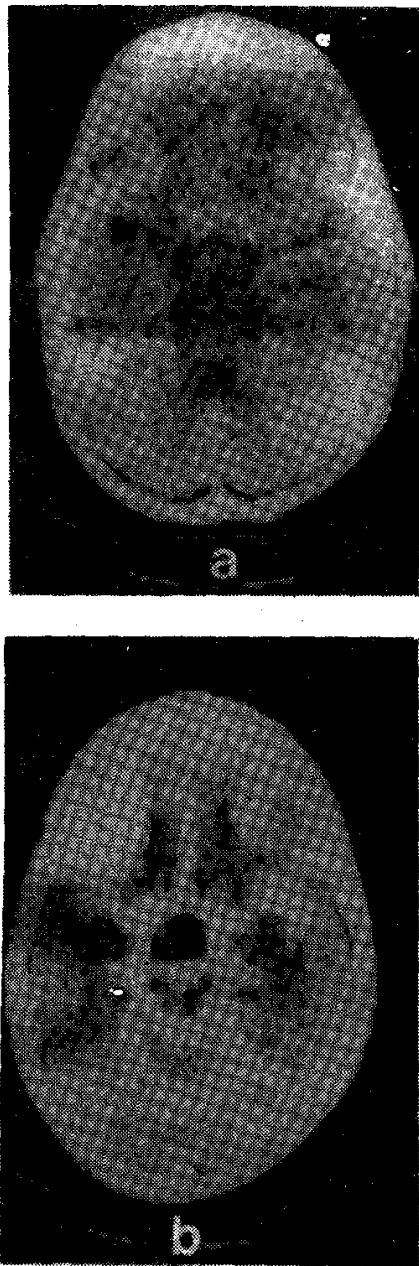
(a) Contrast enhanced CT scan showing an isodense suprasellar mass. (b) CT cisternogram showing the filling defect in the suprasellar cistern by the mass.
